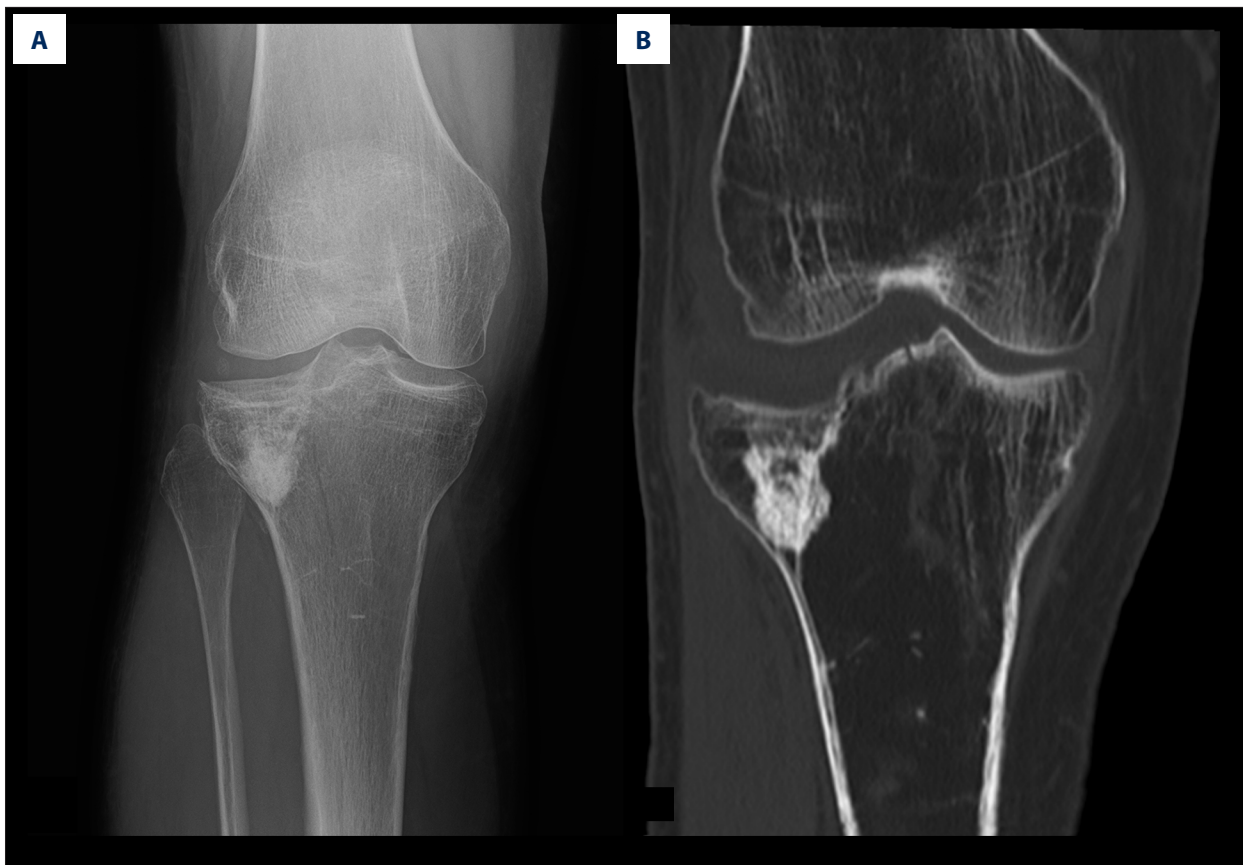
Fracture of the proximal tibia treated by bone substitute material augmentation. (A) Radiograph and (B) CT image following material removal.
